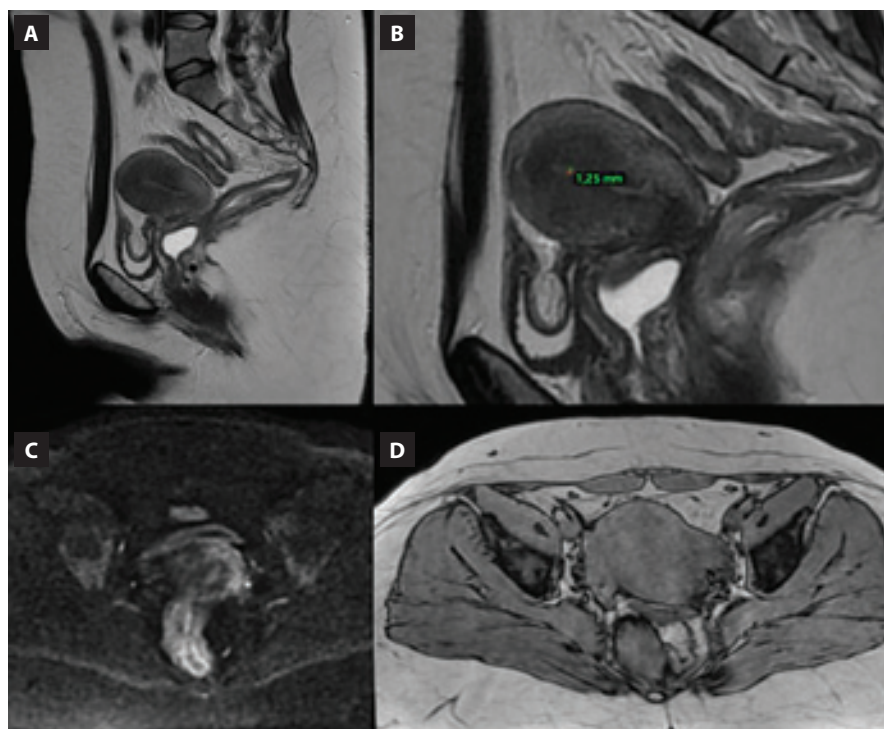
Pelvic magnetic resonance imaging showed a uterus measuring $79 \times 44 \times 40$ mm, with a homogeneous myometrium, no myometrial nodules, and no signs of adenomyosis (A). The endometrium was centrally located, homogeneous, and measured 1.25 mm in thickness (B). The uterine cavity was preserved, with no expansive lesions or disruption of the junctional zone (C and D).
